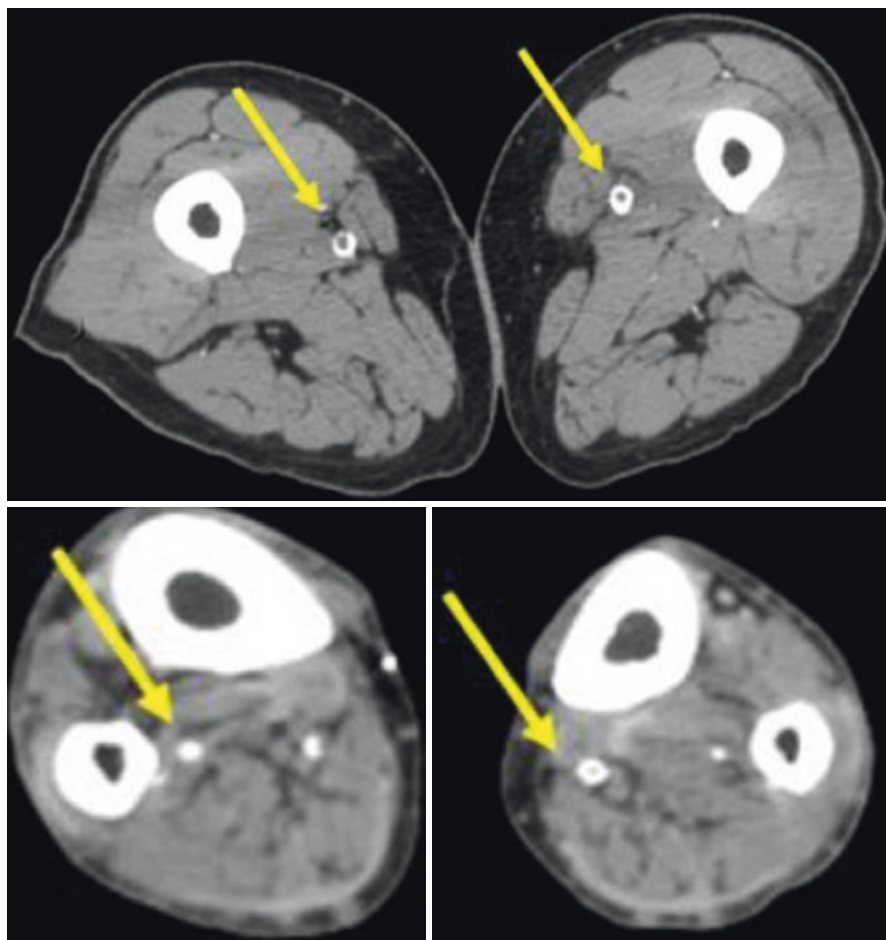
Computed tomography scans of the lower extremity with arrows pointing to calcified arteries
